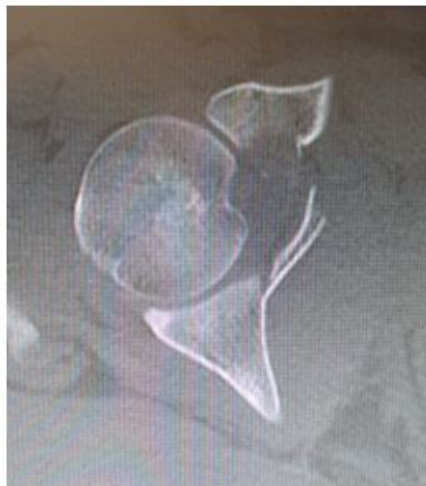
Axial CT scan showing the deviated quadrilateral plate
